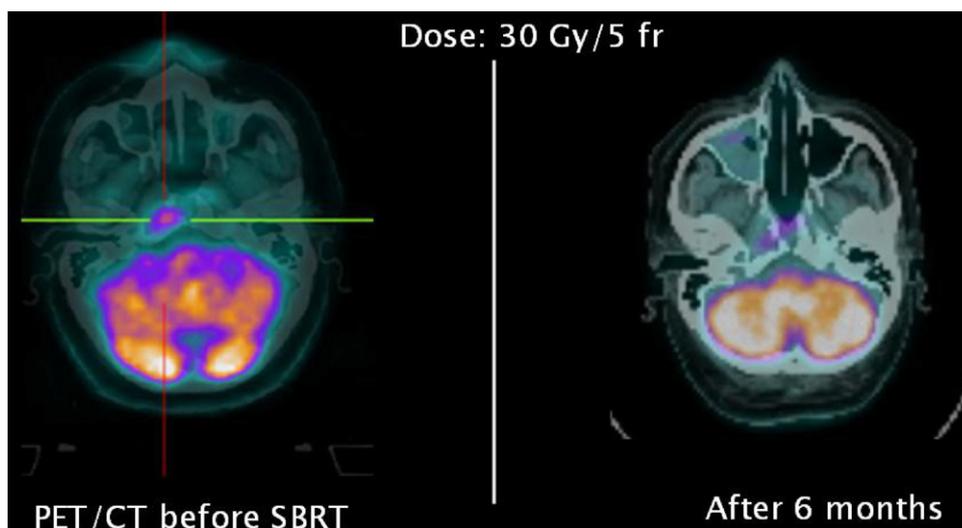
Case 3: Direct comparison of PET/CT axial images before and after the SBRT treatment (30 Gy in 5 fractions), showing a complete response in the site of nasopharynx recurrence.
